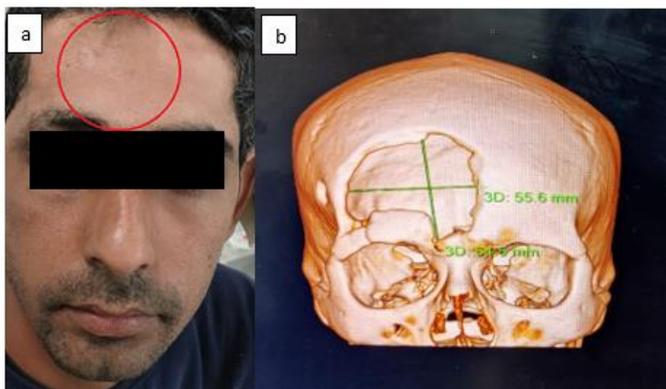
a) Extraoral defect marking, b) Computed tomography 3D, highlighting the limits of bone fracture
